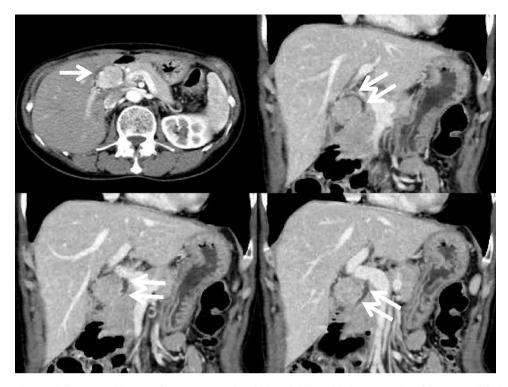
Computed tomography revealed a tumor, with a 3-cm diameter, surrounding the hepatic hilum with the compression of the common bile duct from the outside. The tumor was enhanced in the early phase (single arrow). The extrahepatic bile duct was visible (double arrows).
